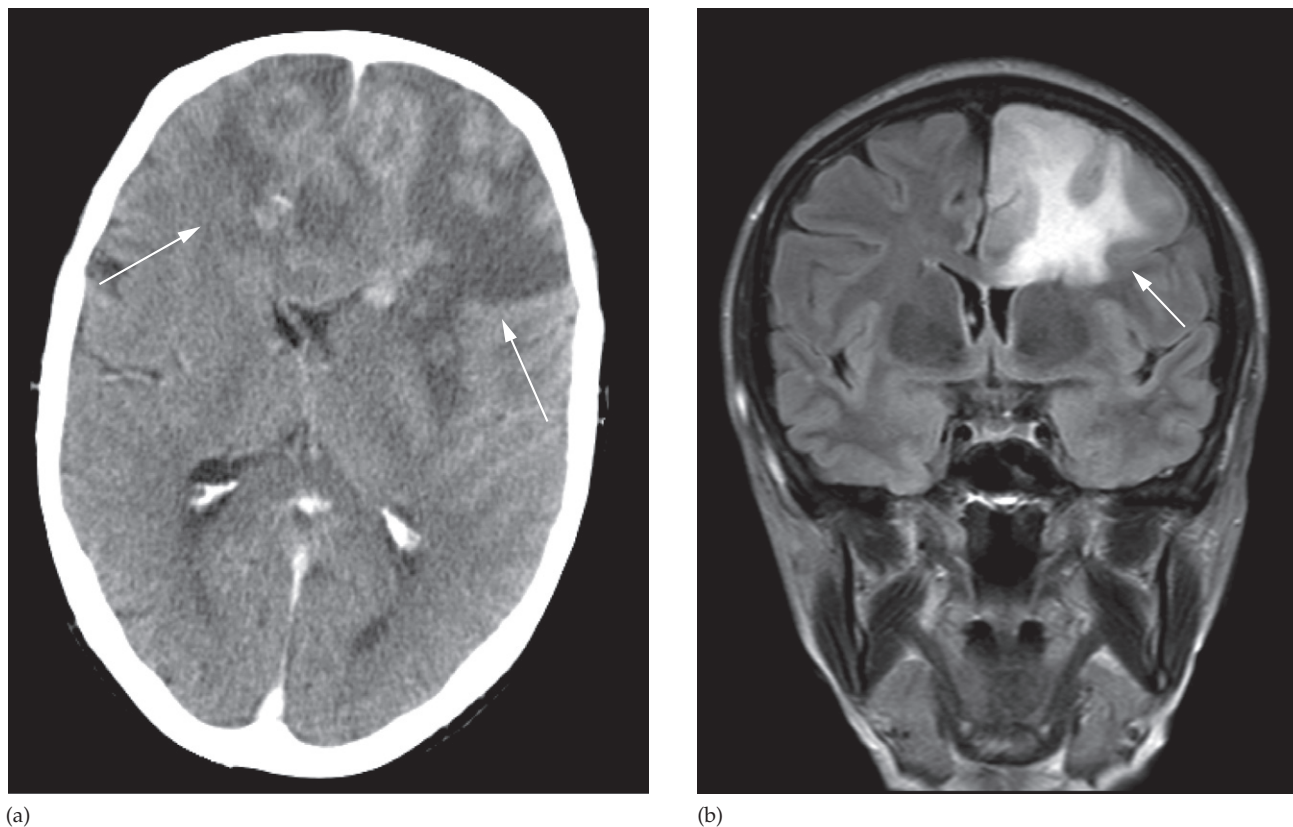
Glioma. (a) CT scan, post intravenous contrast, showing an irregular enhancing mass (arrows) with surrounding low attenuation involving both frontal lobes and the corpus callosum, in keeping with a high grade glioma (glioblastoma multiforme). (b) MRI scan (coronal FLAIR sequence) in a different patient, showing signal change in both the grey and white matter (arrow) with mild mass effect in a glioma (anaplastic astrocytoma).
